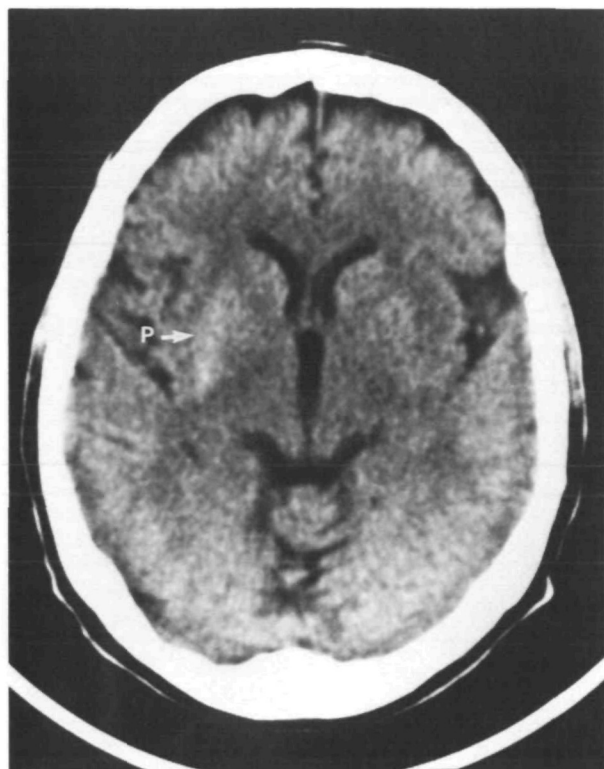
Unenhanced admission axial computed tomography through the basal ganglia.
